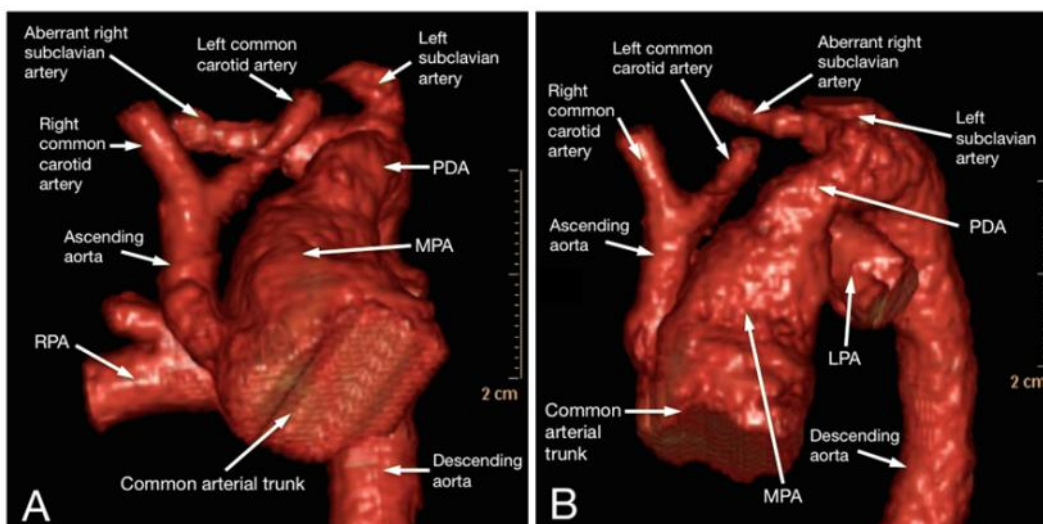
CT images of a cyanotic neonate with truncus arteriosus, interrupted aortic arch and aberrant right subclavian artery. Prior echocardiographic examination was only able to demonstrate truncus arteriosus and classified the anomaly as Collett and Edwards type II (Van Praagh type A2). CT was able to demonstrate a coexistent type B interrupted aortic arch with a hypoplastic ascending aorta, PDA supplying the descending aorta, and aberrant right subclavian artery. The anomaly was reclassified as Van Praagh type A4. MPA = main pulmonary artery, RPA = right pulmonary artery, LPA = left pulmonary artery, PDA = patent ductus arteriosus.
